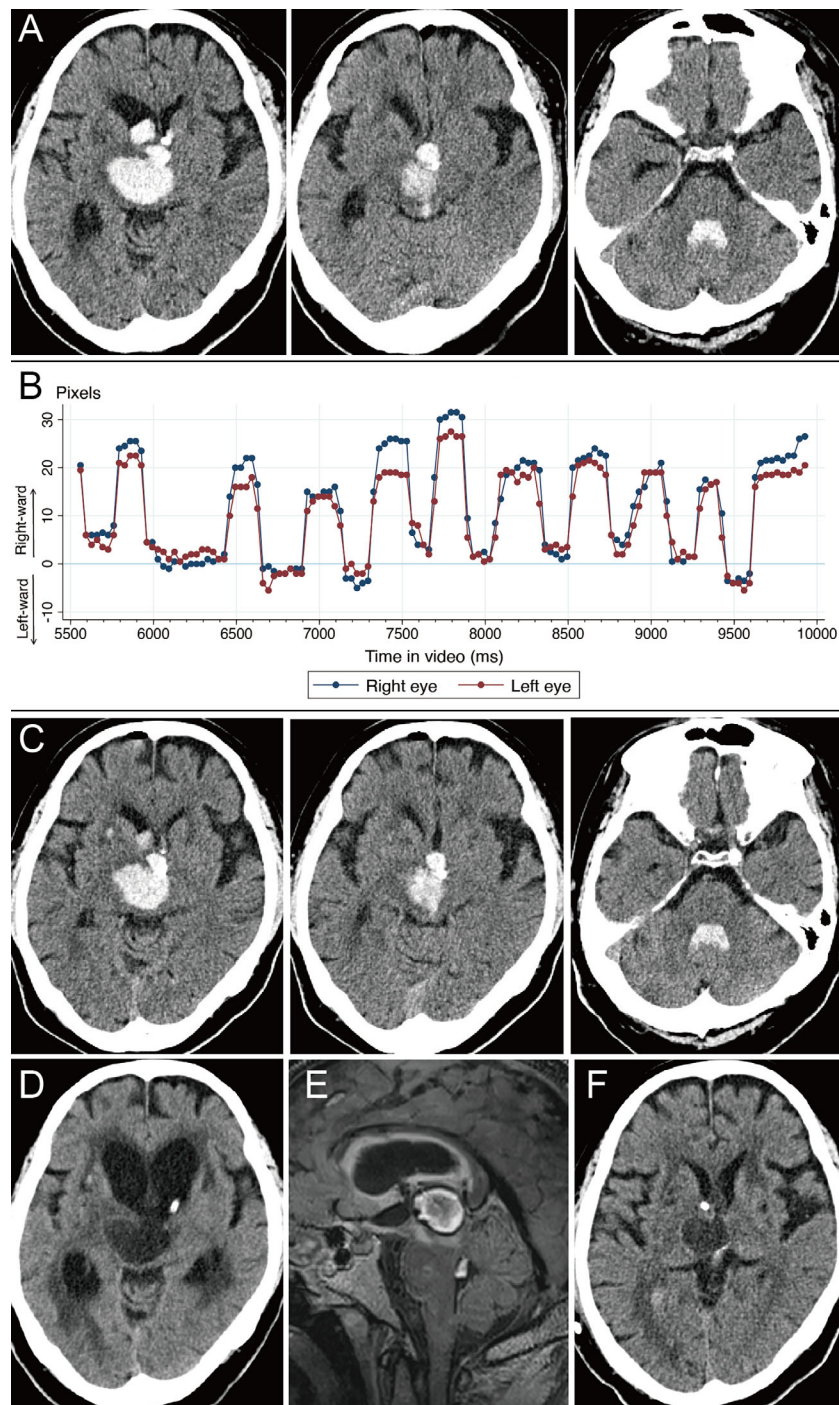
(A) CT on day 1 after ventricular drainage. Hydrocephalus is still evident. The fourth ventricle is filled with hematoma, but there is no hematoma extension into the cerebellar parenchyma. (B) A plot of eye movements observed on day 1, demonstrating conjugate eye oscillations consisting of a right-ward intrusive saccade and corrective saccade. To generate this plot, we analyzed video (MP4 format) at 30 frames per second using freeware motion analysis software (Kinovea). In the analysis, the center of the pupil was tracked in every frame and distances from the initial fixation point were recorded. Eye movement of 20 pixels corresponds with an amplitude of approximately 5° , according to a trigonometric calculation based on the size of the eye ball on CT. Corrective saccades seem inaccurate, which may be due to hand movements during video recording or rotatory movements of the patient's head. (C) CT on day 2 with improved hydrocephalus. (D) After clamping the drainage, hydrocephalus exacerbated. (E) Three-dimensional fluid-attenuated inversion recovery imaging on day 36 shows the presence of subacute clots in the third and fourth ventricles. (F) Cerebral CT on day 40 shows improved hydrocephalus.
